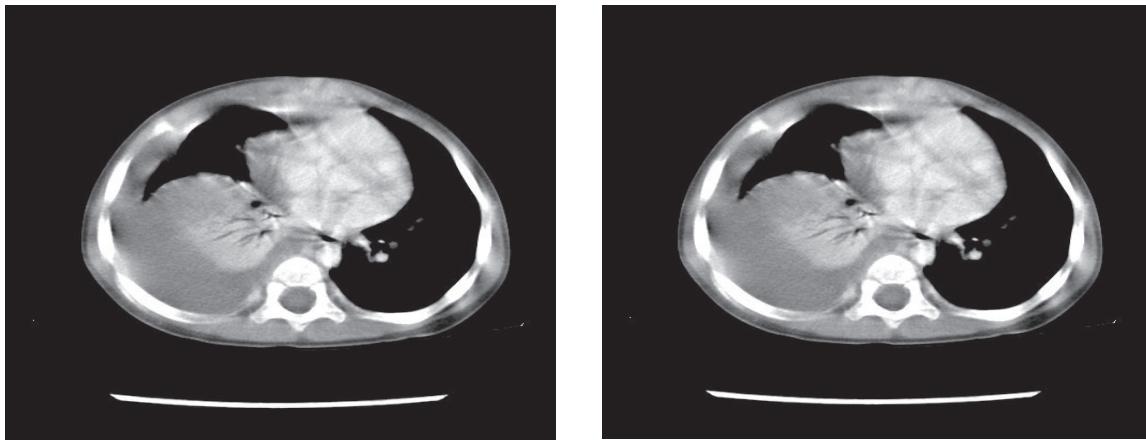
(A-B). Chest CT of the 1st recurrent episode (November 2017)
